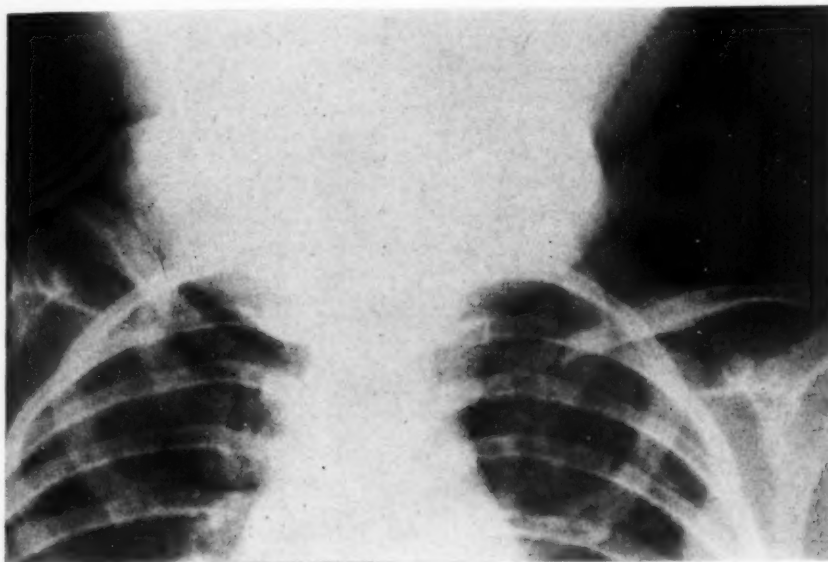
Case I: Roentgenogram of clavicles with periosteal reaction most intense at the central areas.
